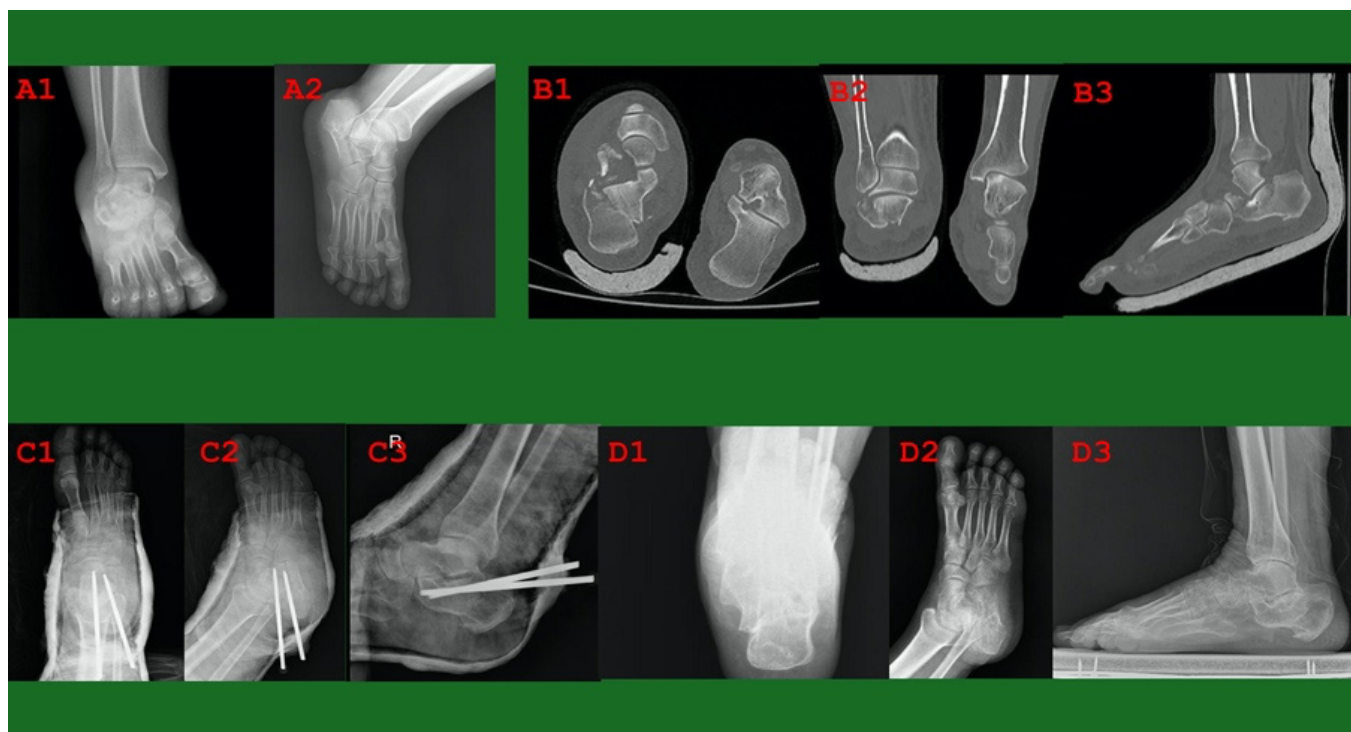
Fifty-five-year-old male admitted after falling from a height. A1. Pre-operative AP radiographs showing comminuted intra-articular calcaneus fracture. A2. Pre-operative lateral radiographs showing comminuted intra-articular calcaneus fracture. B1. Pre-operative computed tomography axial view showing displaced posterior facet of the calcaneus. B2. Pre-operative computed tomography coronal view showing displaced posterior facet of the calcaneus. B3. Pre-operative computed tomography sagittal view showing displaced posterior facet of the calcaneus. C1. Post-operative AP radiographs showing closed reduction and two crossed percutaneous Schanz pin fixation. C2. Post-operative oblique radiographs showing closed reduction and two crossed percutaneous Schanz pin fixation. C3. Post-operative lateral radiographs showing closed reduction and two crossed percutaneous Schanz pin fixation. D1. Control axial radiographs taken 1 year after surgery (AOFAS score: 91). D2. Control oblique radiographs taken 1 year after surgery (AOFAS score: 91). D3. Control lateral radiographs taken 1 year after surgery (AOFAS score: 91)
